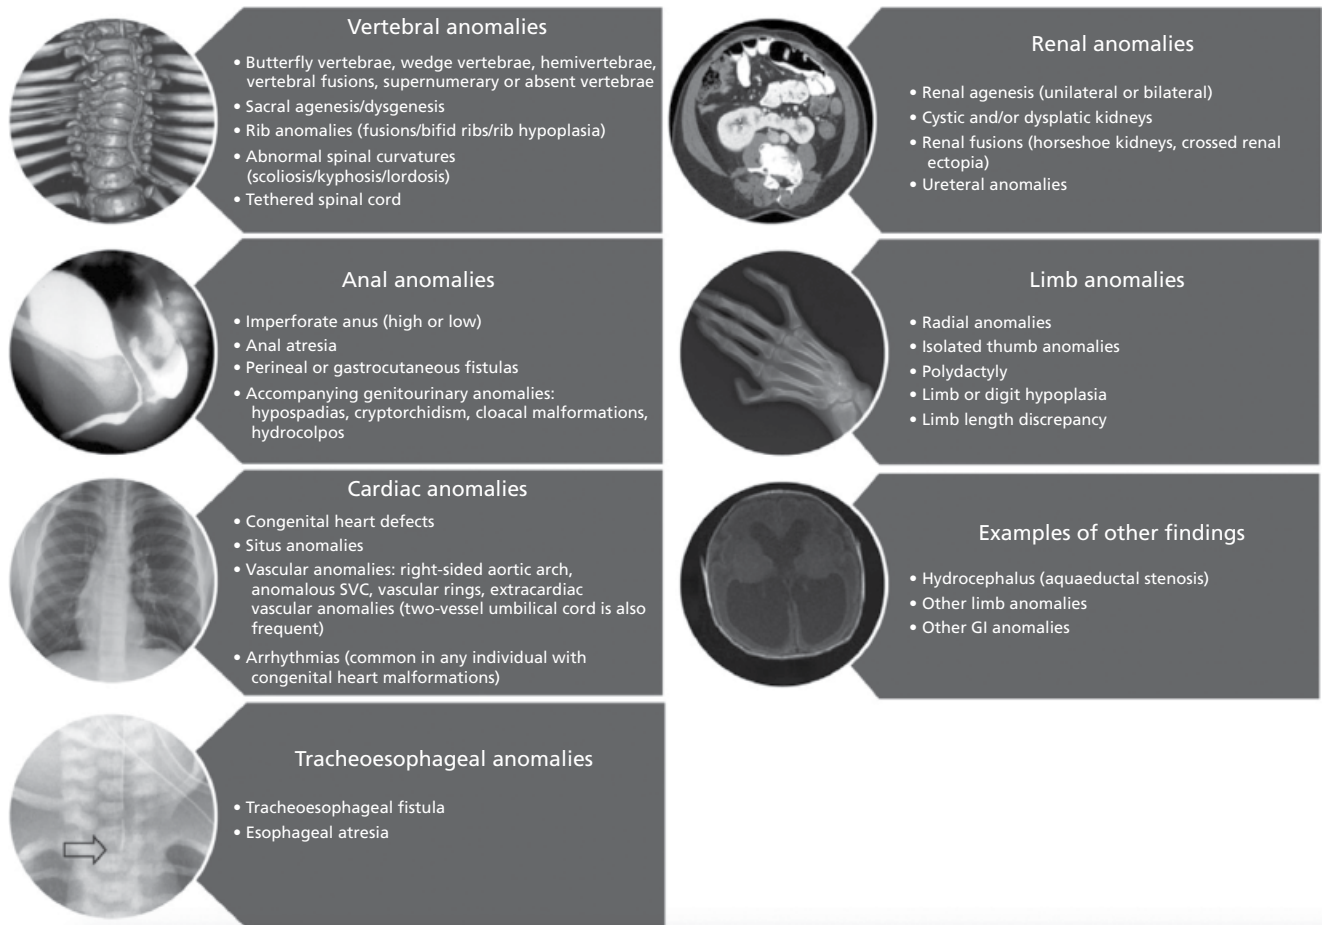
Examples of findings in the VACTERL association. The images in the circles represent radiological examples. Vertebral anomalies: 3D CT reconstruction showing thoracic segmentation anomalies; anal anomalies: contrast imaging showing rectoprostatic urethral fistula in a patient with ano-rectal malformations (ARMs); cardiac anomalies: chest radiograph showing midline heart in a patient with situs anomalies as part of the VACTERL association; tracheo-esophageal anomalies: radiograph showing the position of feeding tube placement (arrow) due to a tracheal pouch; renal anomalies: axial view from an abdominal CT showing horseshoe kidney; limb anomalies: skeletal anomalies affecting the radius, wrist, and thumb; examples of other findings: axial view from brain MRI showing hydrocephalus (due to aqueductal stenosis). GI, gastrointestinal; SVC, superior vena cava. *Source:* Reproduced from Solomon et al [31] with permission of Elsevier.
